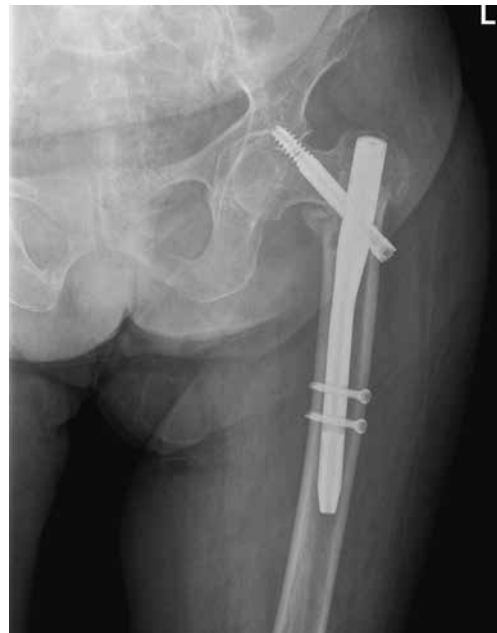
An anteroposterior radiograph of the left hip demonstrating the cut-out of the neck screw at 5 weeks post-operatively.
